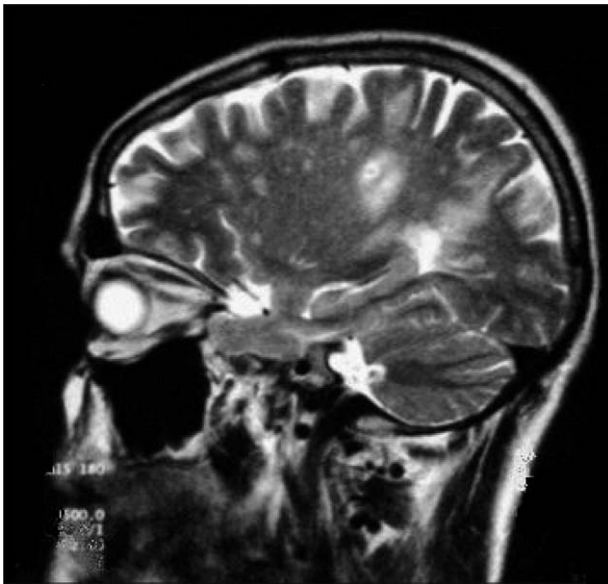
FLAIR-weighted sagittal MRI. Many foci or hypersignal in the white substance subcortical of preference in broadcast crown and semioval centers.
